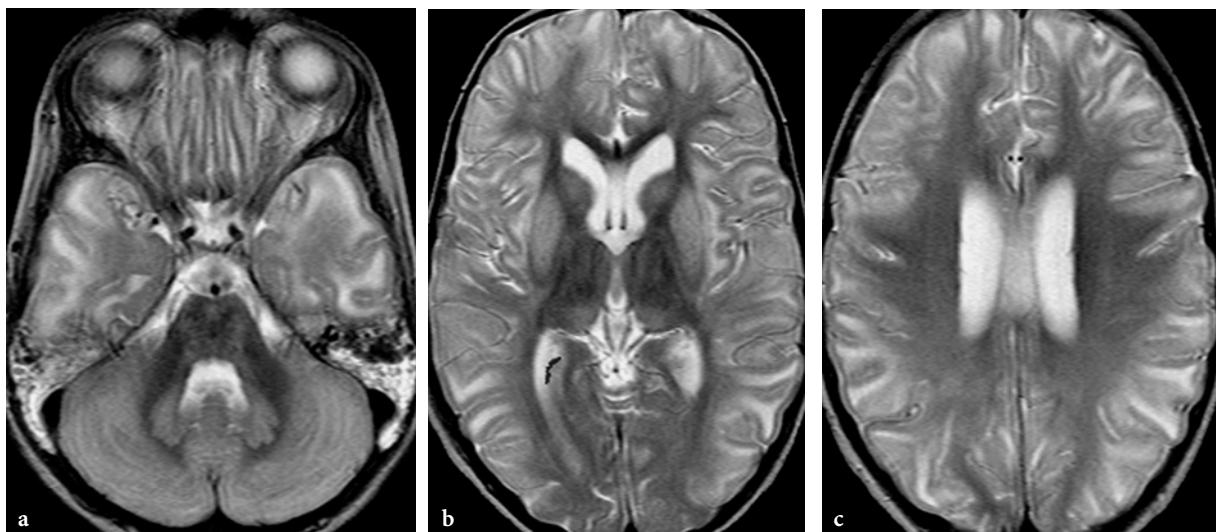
MR imaging findings in propionic acidemia in acute metabolic crisis. Axial T2-weighted fast spin-echo images in a 6-year-old female patient, immediately after the first metabolic decompensation of her life. a Prominent, abnormal hyperintensities within the dentate nuclei, but ill-defined signal changes are also seen within the pons. b Symmetrical signal abnormalities are present within the heads of the caudate nuclei, putamina and the pulvinar of the thalami. c Dominantly subcortical white matter changes within the cerebral hemispheres (note similar changes on other images as well). The cerebral cortex appears to be abnormally hyperintense too
